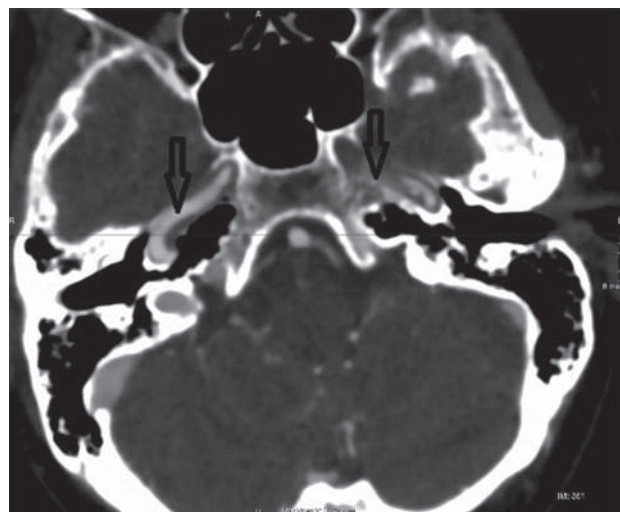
CT angiogram shows a normal filling petrous portion of right ICA but an occluded left ICA (arrows point at ICA – compare right and left lumen sizes). CT = computed tomography; ICA = internal carotid artery.
